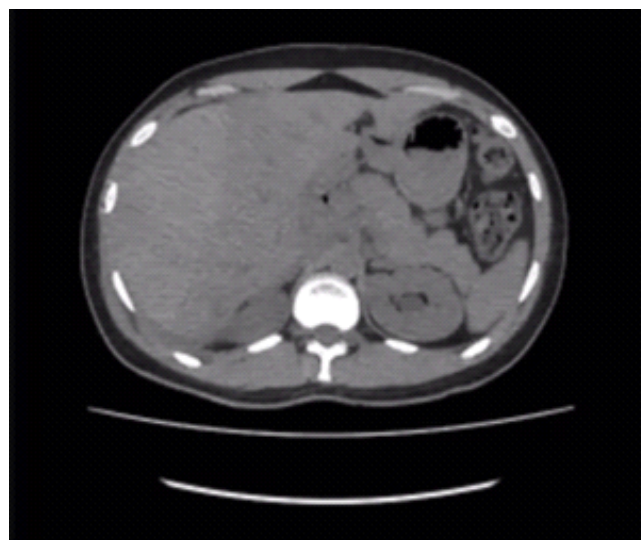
Contrast-enhanced computed tomography scan demonstrating a subcapsular haematoma of the right lobe of the liver with no contrast extravasation.
